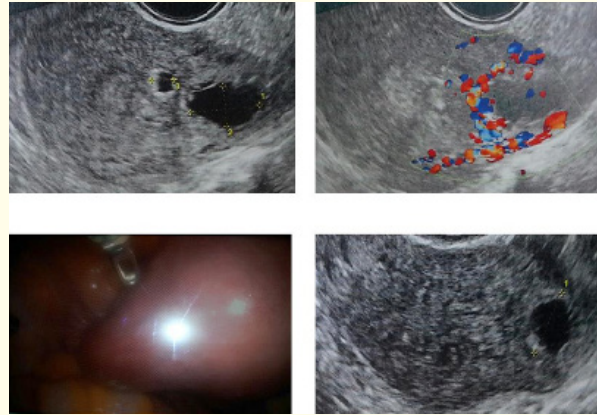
Interstitial pregnancy. Bidimensional, Color Doppler and Laparoscopic view.
